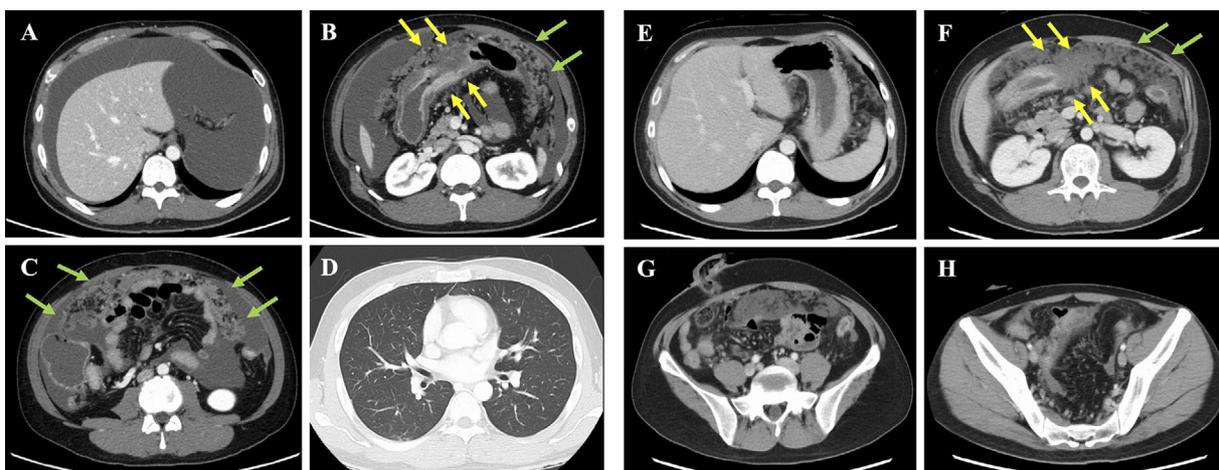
Computed tomography images before and after chemotherapy. Before chemotherapy, images depict massive ascites in the abdominal cavity (A-C), the primary lesion in the transverse colon (B, yellow arrows), multiple peritoneal disseminations (B, C, green arrows), and the absence of hepatic and pulmonary metastases (A, D). Following chemotherapy, there was a decrease in ascites (E-H), no significant changes in the primary lesion, and multiple peritoneal dissemination (F, yellow and green arrows).
